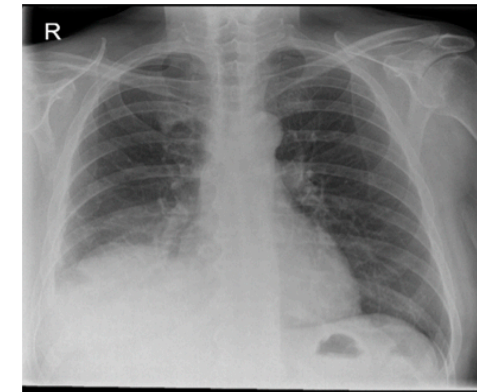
Examples of (a) normal and (b) abnormal P_{EL} curves with corresponding radiographic appearances from EDIT management cases
